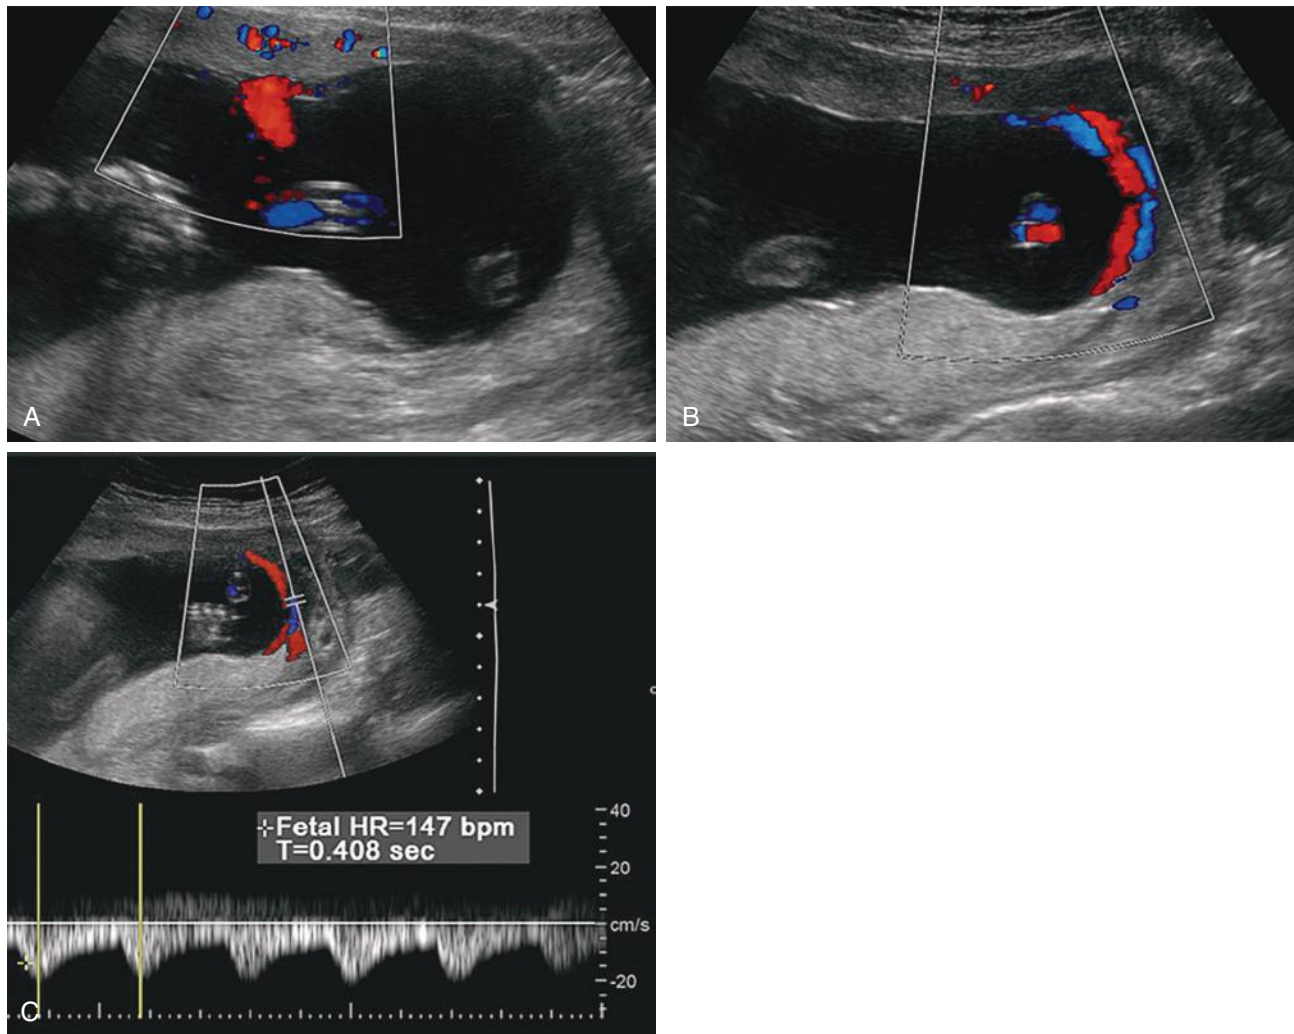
Succenturiate lobe. A, In this 20-week gestation, the umbilical cord inserts at the main body of the placenta, which is implanted anteriorly. B, Color Doppler sonography shows vessels connecting the main portion of the placenta to a posterior succenturiate lobe. C, Spectral Doppler interrogation of the arterial vessels connecting the succenturiate lobe to the placenta demonstrates a normal fetal heart rate (HR), 147 beats per minute (bpm).
